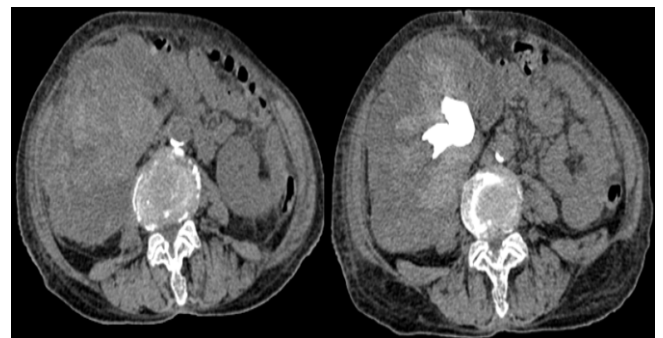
Plain CT axial view showing hypodensity area within the right renal mass
